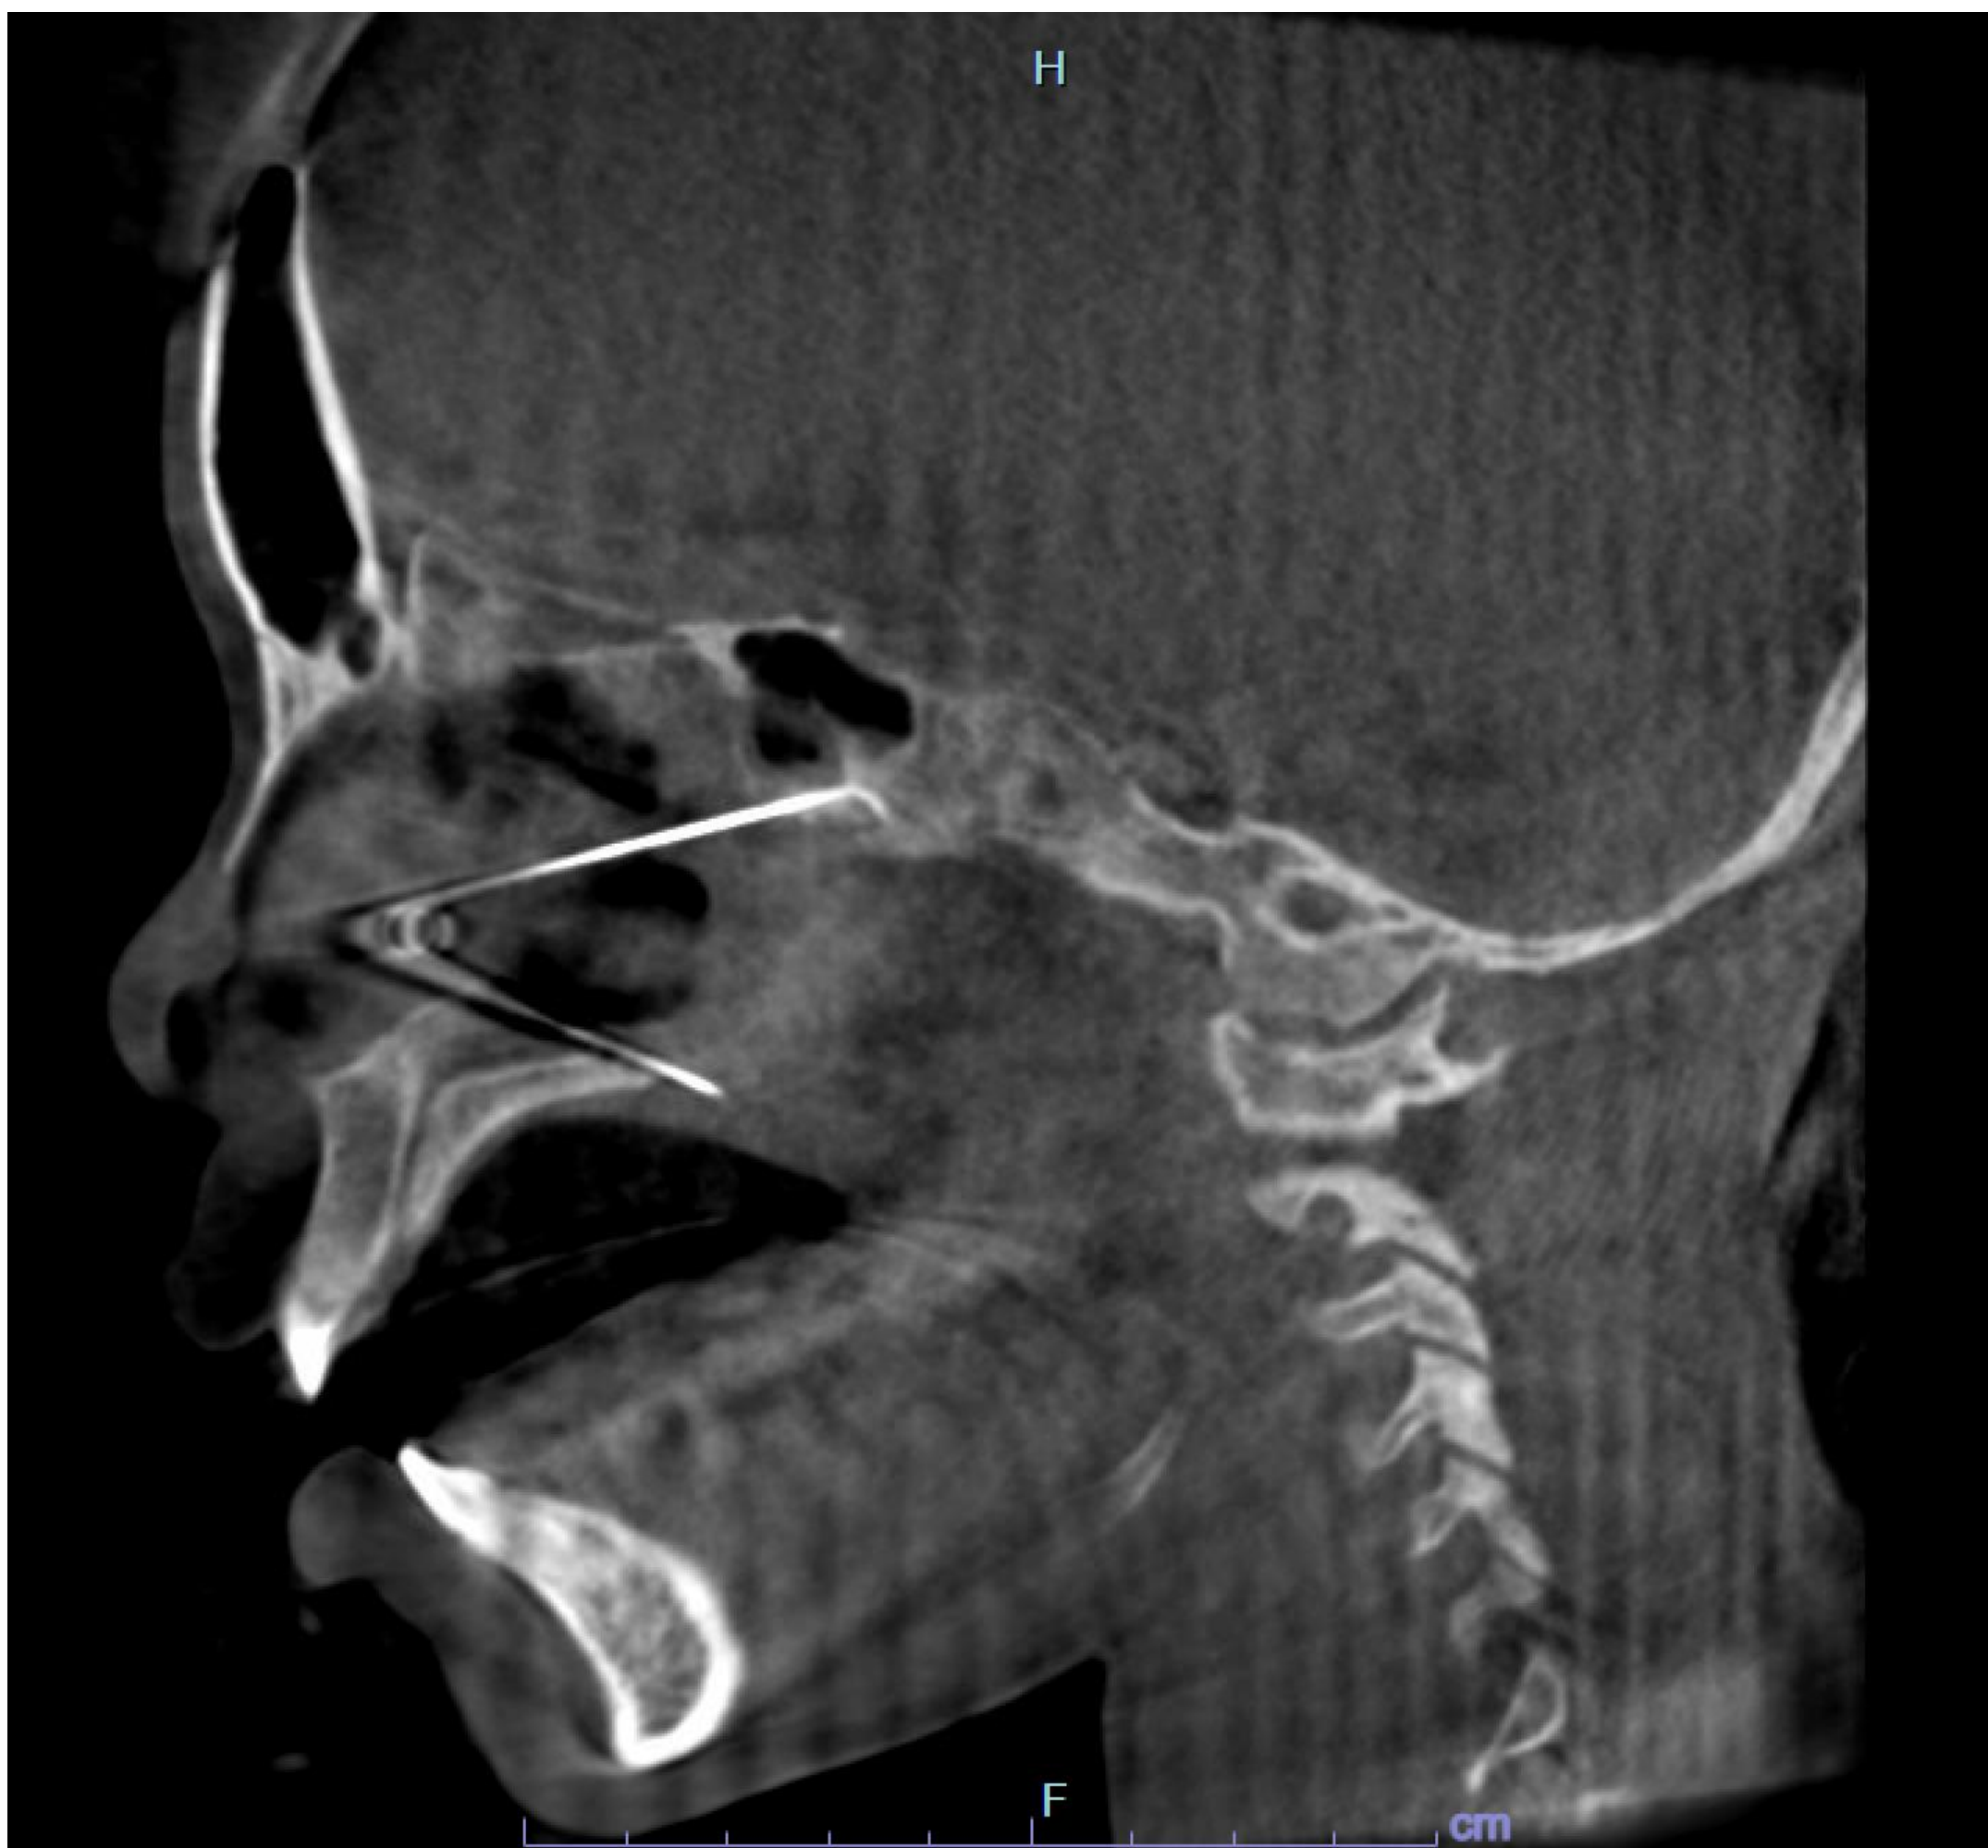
Intraoperative CT indicating open safety pin extending to skull base
